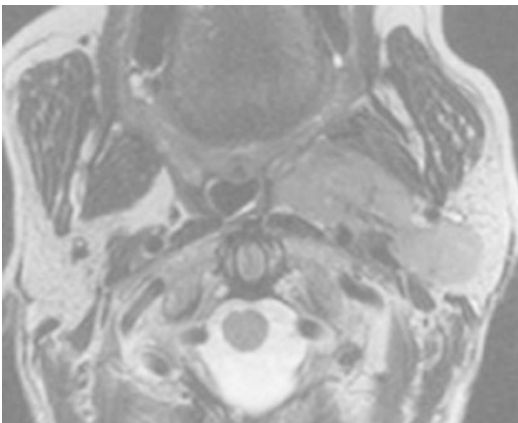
Parapharyngeal tumors that demonstrate passage through the stylomandibular tunnel (as shown on axial CT scan) are not candidates for the transoral robotic approach due to an increased risk to the facial nerve
